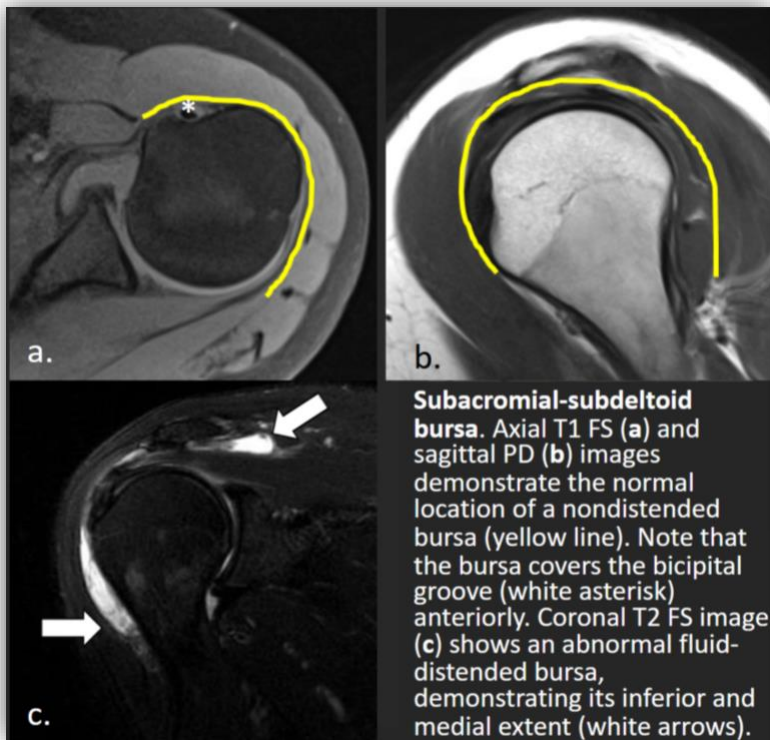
Axial (a), sagittal (b), and coronal (c) MR images demonstrating normal and distended appearances of the subacromial-subdeltoid bursa.
